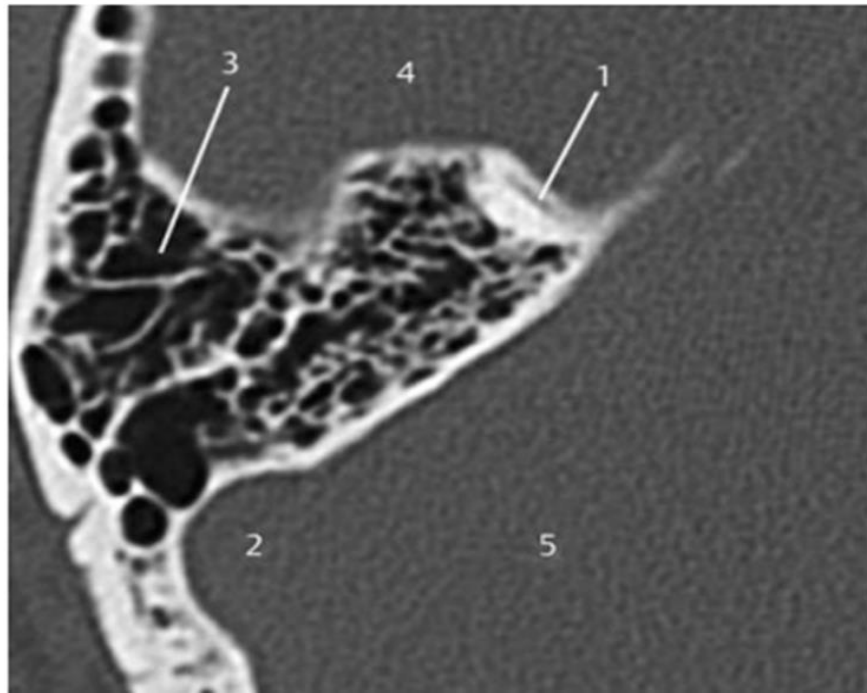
CT axial cut of right side temporal bone. 1-anterior semicircular canal,2-sigmoid sinus,3-highly pneumatized mastoid bone,4-middle cranial fossa, 5-posterior cranial fossa¹².
